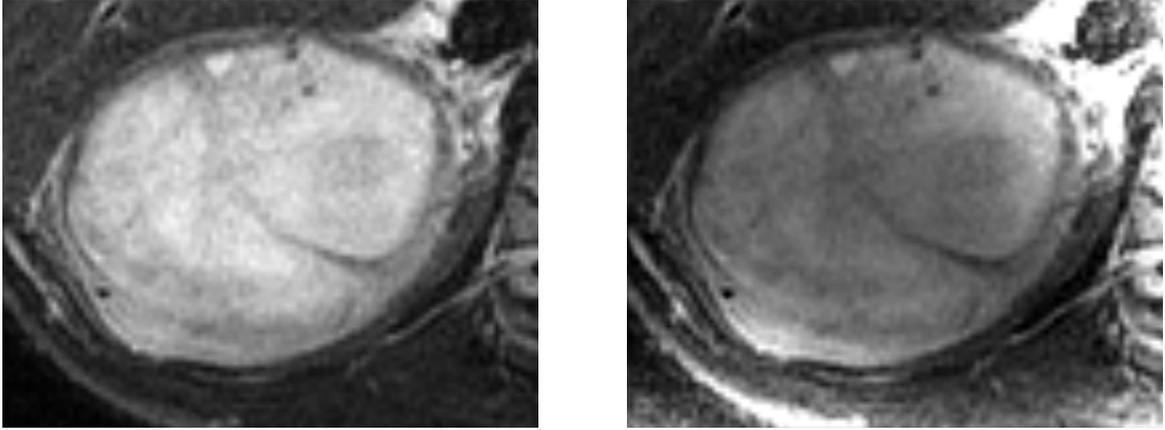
uncorrected (left) and bias-corrected tumour tissue in a MRI image (right)
